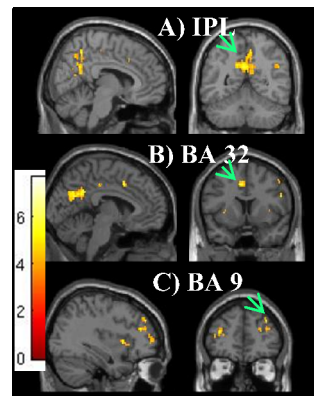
T-statistics overlaid on T1-weighted structural scan from paired t-test ($N=18$, $p_{unc}=0.001$, $k=25$) of HRES data set ($32Ch_{two-thirds} > 12Ch_{full}$ contrast). Activations in IPL, BA32 and BA9 are shown with green arrows in (A), (B) and (C) respectively. The opposite contrast ($12Ch_{full} > 32Ch_{two-thirds}$) did not reveal any regions of activation. The 32Ch data set that went into the analysis had 33% time-points lesser compared to the 12Ch data set.
